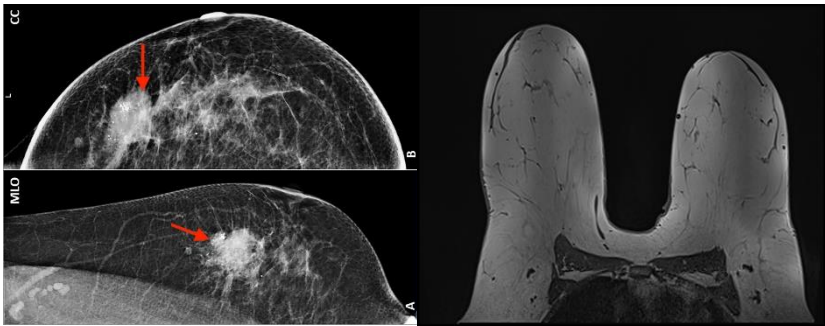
MRI scan comparison showing normal tissue vs. malignant tumor development in breast cancer. Such differences can be subtle and often require computational assistance through machine learning to detect at early stages.
